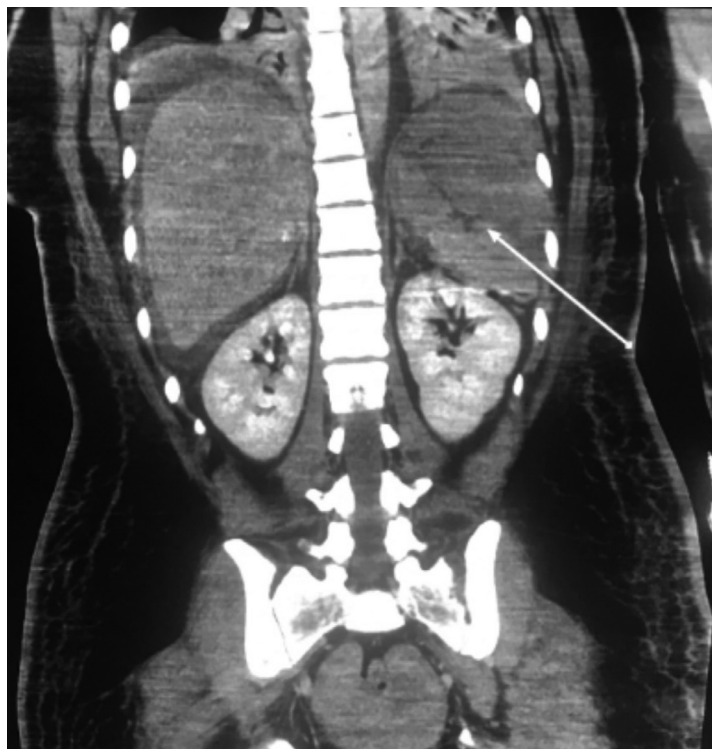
Computed tomography of the abdomen in coronal view demonstrating irregular border of the splenic parenchyma, indicating a ruptured spleen (arrow) and an extensive amount of fluid within the abdominal cavity.
